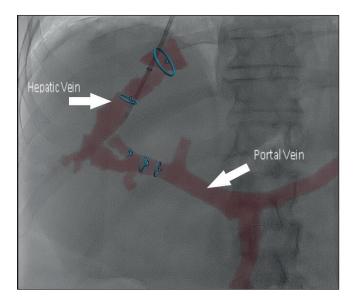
CT guided fusion imaging
